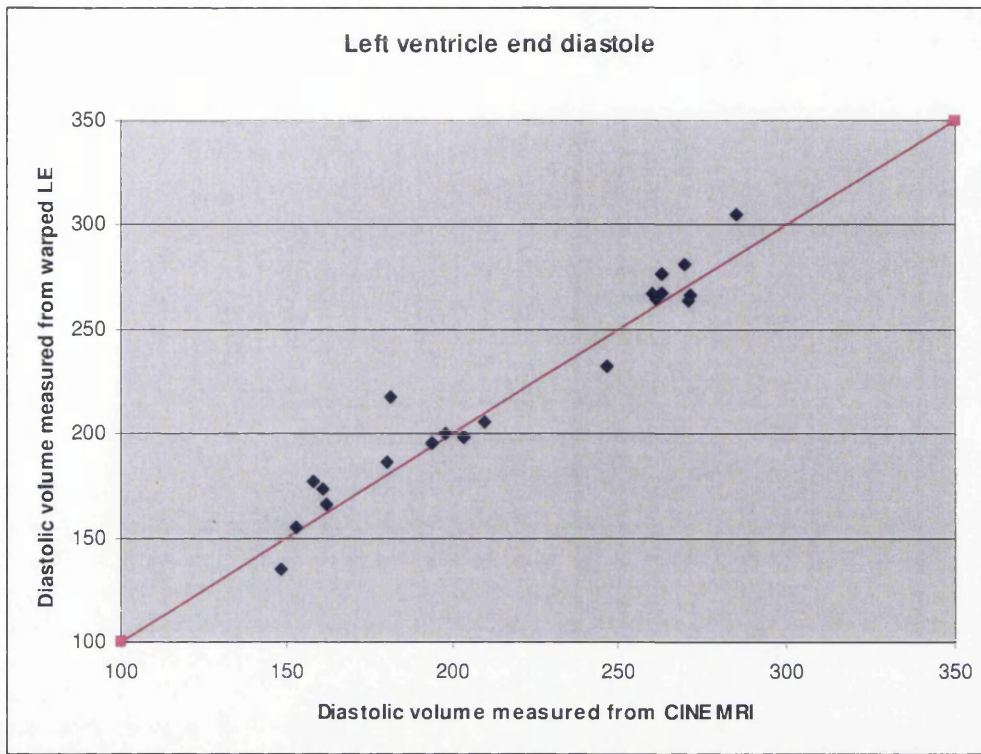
The comparison between the cine contrast enhanced MR images and the original cine MR images.
